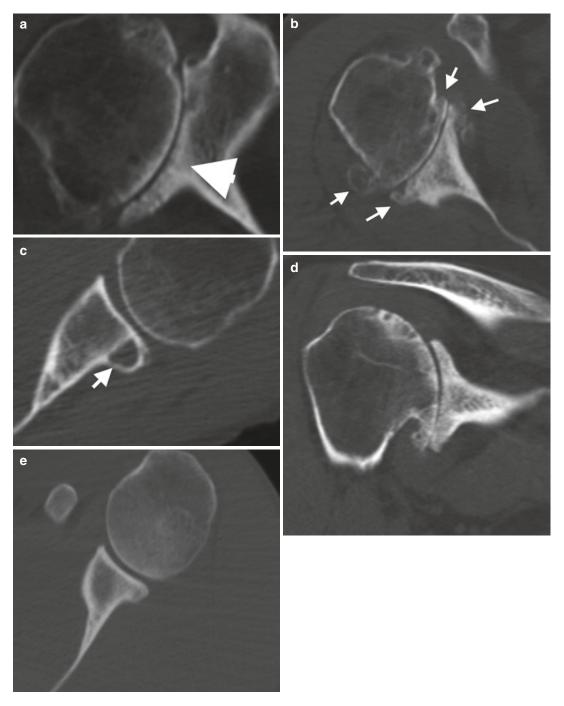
CT secondary degenerative joint disease on the right shoulder. (a) Subchondral sclerosis/eburnation (*arrowhead*); (b) moderate osteophytosis (*arrows*); (c) subchondral cyst glenoid with well-defined sclerotic margins
